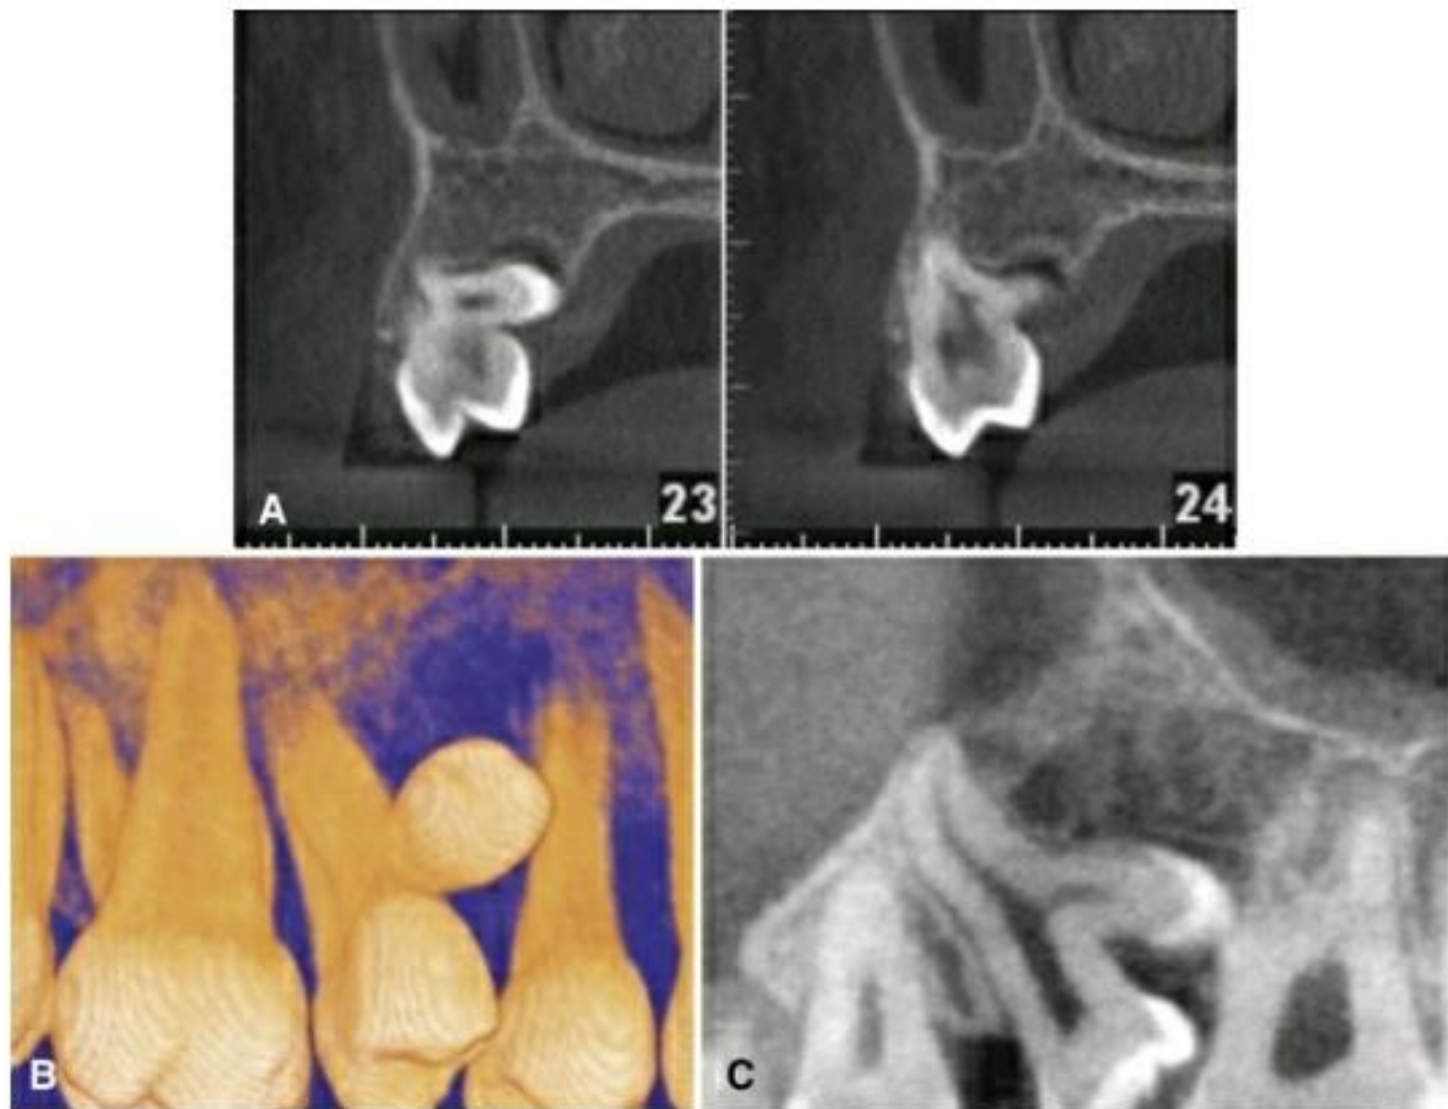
(A) Gemination of a maxillary left second premolar on cross-sectional slices. (B) Three-dimensional surface rendering demonstrating the geminating tooth and its association with the premolar. (C) Coronal cone beam computed tomography image of another case of gemination of a second premolar. Note the common root canal. ([A and B] Courtesy Dr. B. Friedland, Cambridge, MA.)
